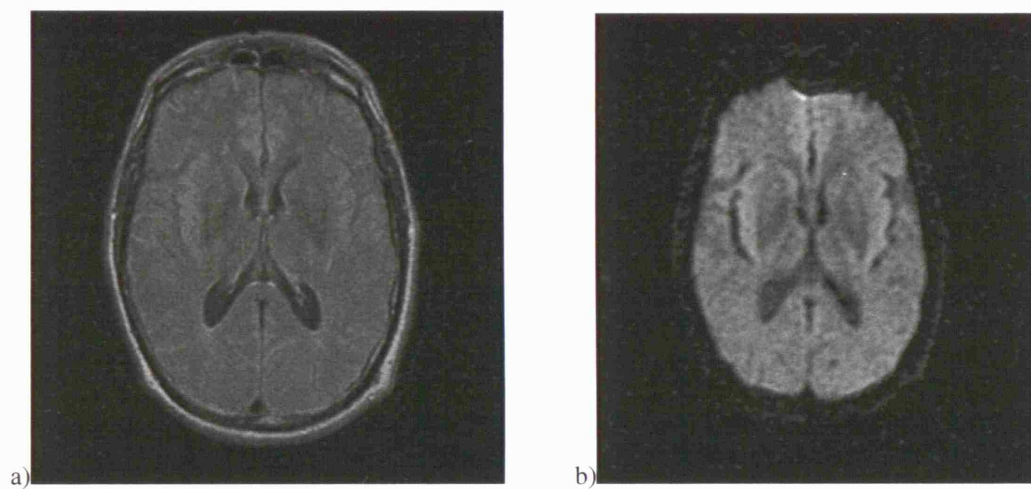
a) Axial FLAIR image and b) Axial DWI image (b=1000) from a symptomatic patient with inherited prion disease (P102L mutation)
